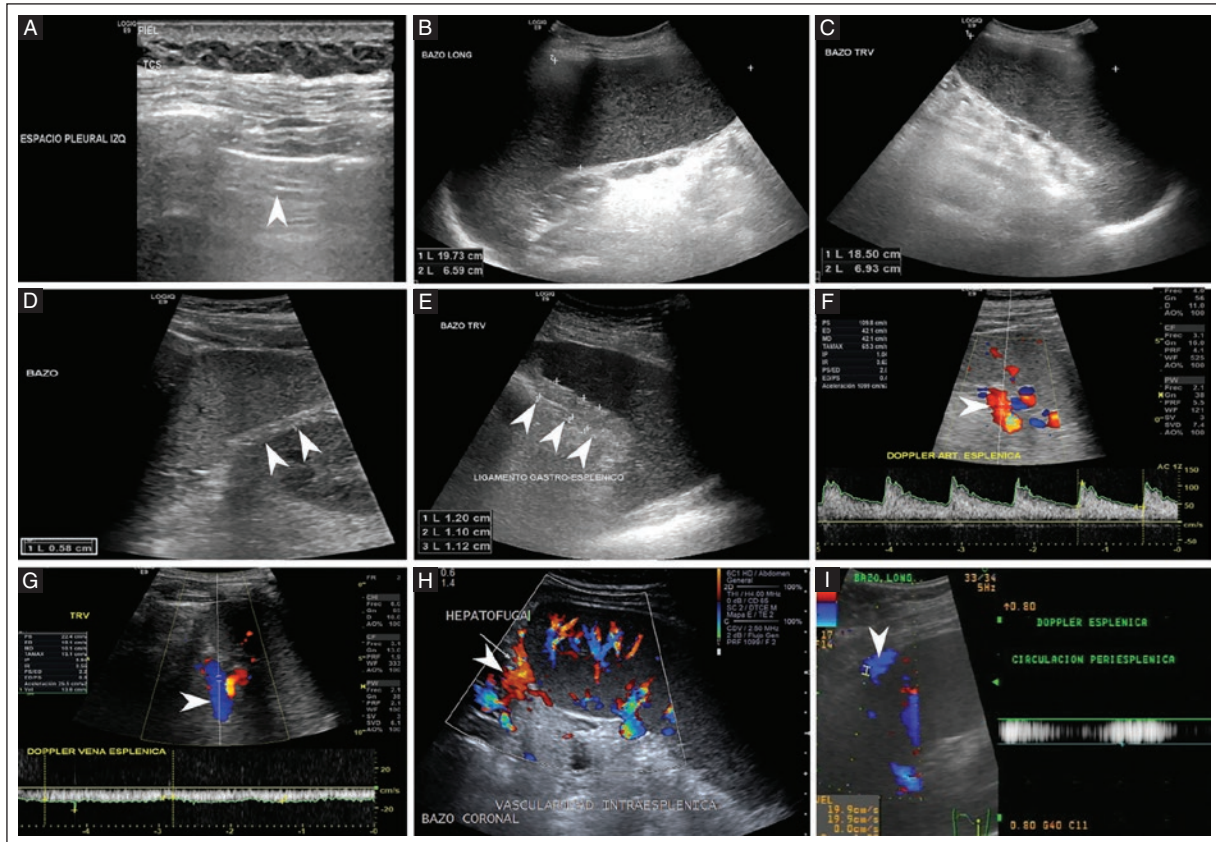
Morphologic US duplex findings of the splenic region in portal hypertension assessment. A: a 71-year-old man with CLD. Grayscale US, sagittal view with high-frequency linear transducer (10 MHz) with normal left pleural space (white arrowhead) without pleural effusion. B-C: a 59-year-old woman diagnosed with CLD. Grayscale US, longitudinal and transverse view, with longitudinal (19.7 cm), anteroposterior (6.5 cm), and transverse (18.5 cm) diameters and a spleen volume of 1,238 cm³ (not shown). D: a 27-year-old man with CLD, sagittal view of the spleen in grayscale US with normal gastro-splenic ligament (5.8 mm) (arrowheads). E: a 78-year-old woman with CLD, transverse view of the spleen with thickening of the gastro-splenic ligament (11 to 12 mm) (arrowheads). Hemodynamic US duplex findings of the splenic region in portal hypertension assessment. F: US duplex of a 30-year-old man with CLD, transverse view, showing splenic artery with patency; spectral morphology with a slight increase in velocity (109.8 cm/s) (arrowhead). G: US duplex of a 40-year-old man, transverse view, showing the splenic vein with patency, hepato-petal flow, and normal velocity of 22.4 cm/s (arrowhead). H: color Doppler US of a 46-year-old man with CLD, transverse view, showing increased intrasplenic vascularity and hepatofugal flow in the upper perisplenic area (white arrowhead). I: a 59-year-old woman with CLD, US duplex Doppler, sagittal view, showing perisplenic hepatofugal flow in the upper and subphrenic areas (arrowhead).
